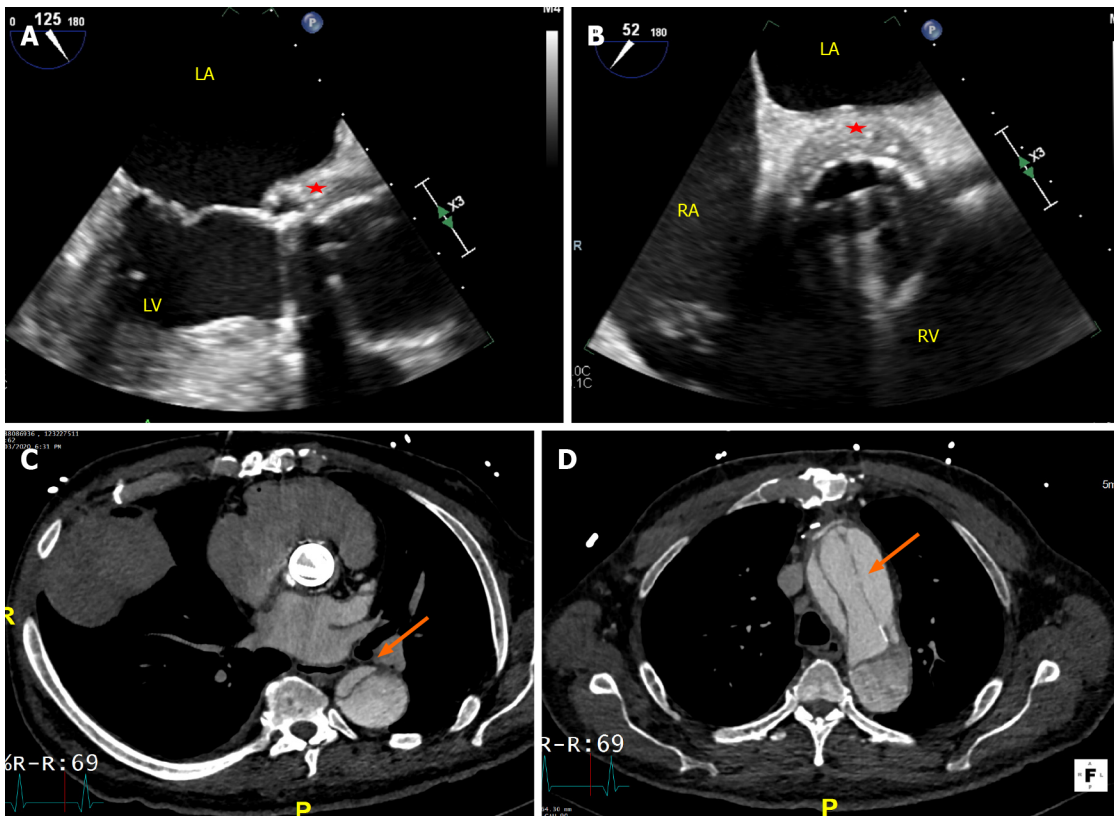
Transesophageal echocardiogram and cardiac computed tomography in a patient with metallic aortic valve replacement endocarditis, complicated by aortic dissection. Sixty-two year-old male with a history of type A aortic dissection status post repair with #27 CarboMedics valve conduit with reimplantation of the coronary arteries, #28 mm Hemashield bridge graft to the distal ascending aorta, presenting with PVE and extension of dissection from the distal ascending aorta to the femoral arteries. His transesophageal echocardiogram demonstrated the presence of a metallic AVR with pathological thickening of the aorto-mitral curtain and aortic root posteriorly (A and B: Star). Cardiac computed tomography axial view of the metallic aortic valve demonstrated widely open occluders and further inspection of the aorta at the level of the arch demonstrated the aortic dissection extending into the descending thoracic aorta (C and D: Arrow). RA: Right atrium; RV: Right ventricle; LA: Left atrium.
